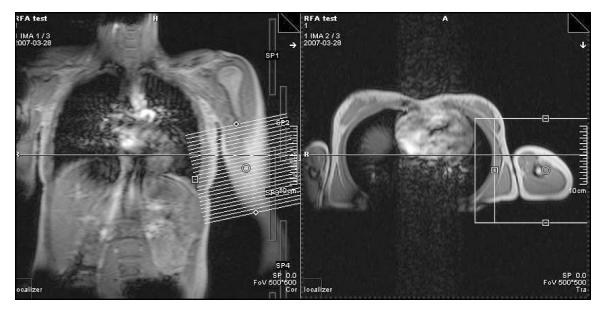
MRI slices with a thickness of 5 mm and a distance between the slices of 1.5 mm were chosen representing the upper arm region between the axilla and elbow joint. The slices were localized using coronal (left) and axial (right) scout images. During evaluation, the slice presenting the lower m. deltoideus tendon attachment and the 11 slices distal of the first slice were included.
